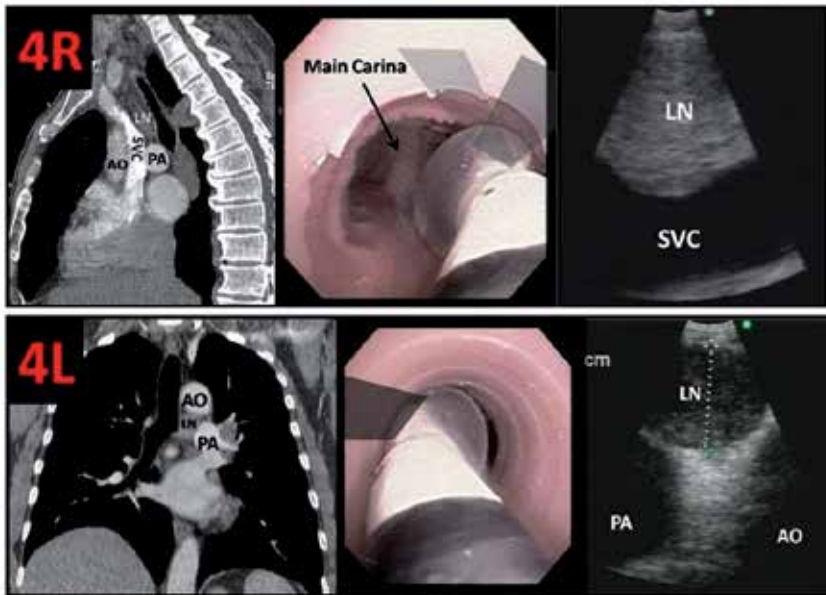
Sagittal CT, bronchoscopic image and EBUS image of station 4R and 4L lymph node stations [106]. Courtesy of Septimiu Murgu, MD and Henri Colt, MD; Bronchoscopy International www.bronchoscopy.org
